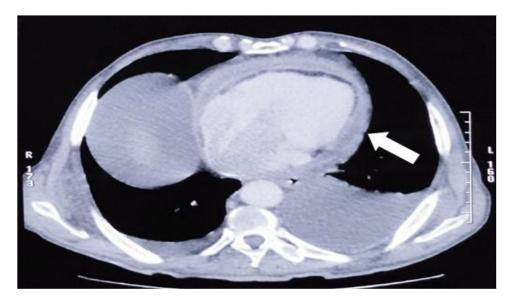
Computed tomography demonstrates pericardial thickening (white arrow).
